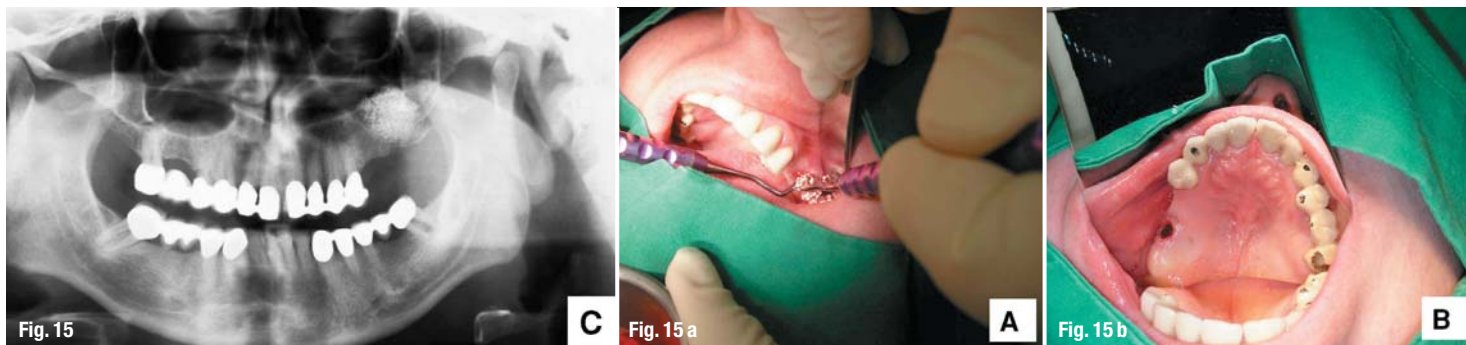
Case report, patient Z. E., 43 year-old male: (a) Augmentation mixture put through the bore hole into the submucosal space. (b) Final view of the operation site before closing the soft tissue defect with the gingiva punch kept in sterile saline (mirror view). (c) Panoramic x-ray scan with the implanted augmentation material.
